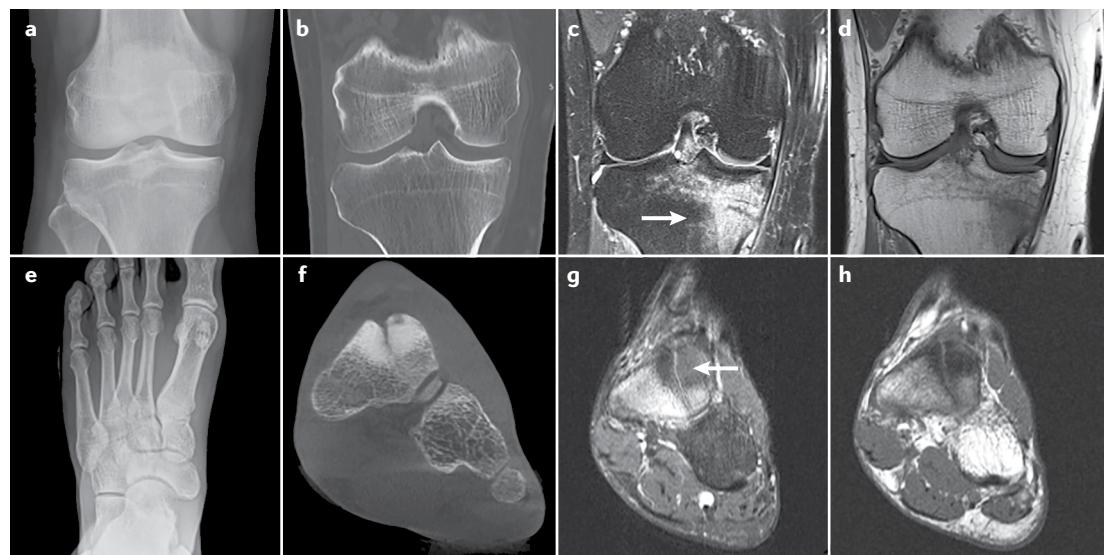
Imaging modalities for exemplary bone stress injuries. a–d | Bone stress injury to the medial tibial head. e–h | Bone stress injury to the os naviculare. Plain radiographs (parts a and e) are insensitive to detect bone stress injuries, but periosteal callus or cortical thickening can be indicative of a bone stress injury. CT (parts b and f) is rarely recommended but provides excellent osseous imaging. To date, MRI is the modality of choice. The typical signal characteristic is a hyperintense oedema (arrow) in fat-suppressed (T2-weighted) imaging (parts c and g) with corresponding hypointense signal on T1-weighted images (parts d and h). Anterior–posterior view is depicted in parts a–e and coronal view in parts f–h.
